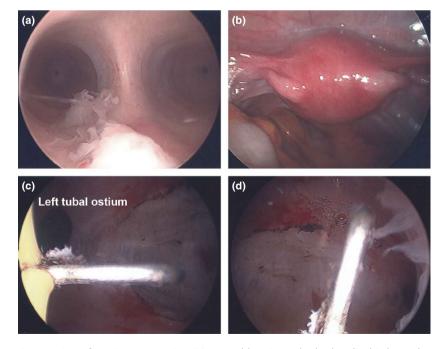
Hysteroscopic resection of uterine septum in a 33-year-old patient who had no livebirths and two spontaneous miscarriages at 11 weeks and 8–9 weeks gestation after fetal heart beats had been detected on ultrasound scan. (a and b) Pre-operative views showing septum (a) and normal external uterine fundal contour (b). (c and d) Post-resection views. Note that the cutting knife electrode (Collin's electrode) of the resectoscope is visible.
